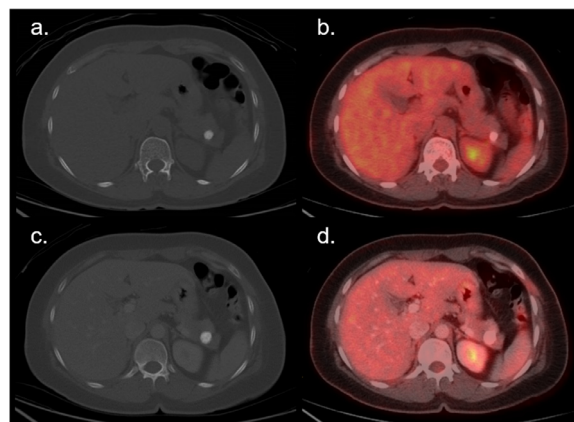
Osteosarcoma metastasis. (A - D) 51 y/o female with osteosarcoma metastasis. At baseline (A) CT and (B) fused ^{18}F -FDG PET/CT show an entirely calcified metastasis in the pancreatic tail without corresponding ^{18}F -FDG uptake. At follow up (C) CT and (D) fused ^{18}F -FDG PET/CT show increase in size without corresponding ^{18}F -FDG uptake.
